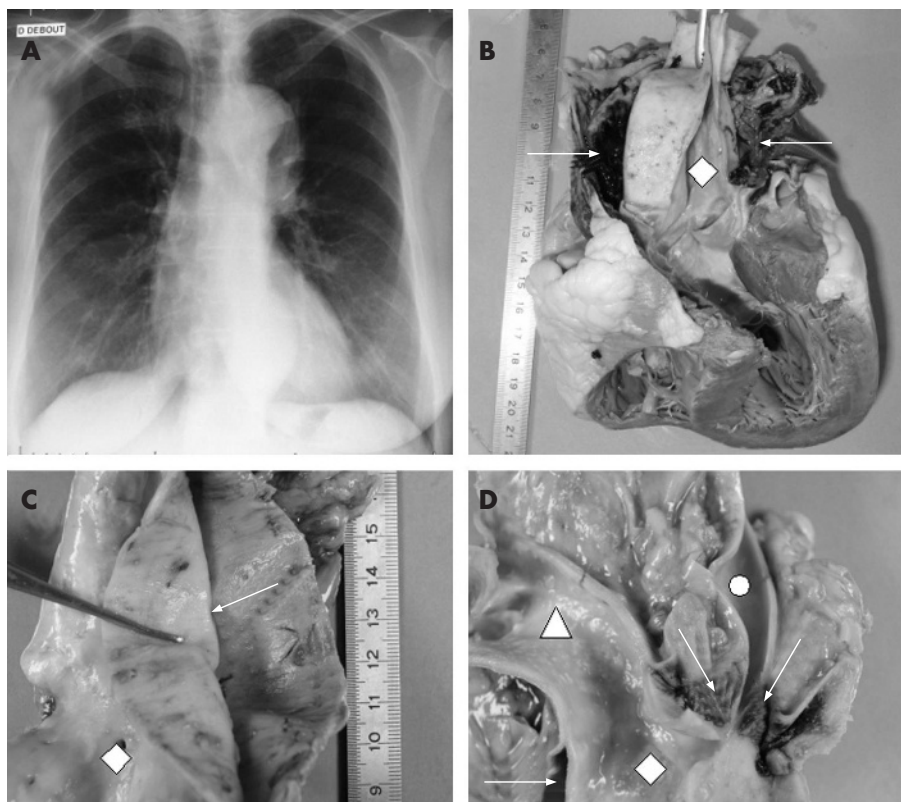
(A) Chest radiograph of the patient. (B) Heart: frontal section through aorta. (C) Aortic walls, delimiting false lumen (thoracic portion). (D) Aortic cross, showing preservation of cervical arteries. Diamond: aortic lumen; circle: right primitive carotid; arrows: false lumen; triangle: brachiocephalic trunk.
